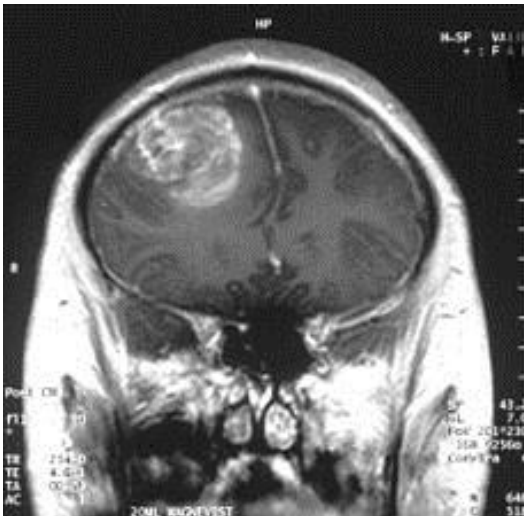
Magnetic Resonance Imaging (MRI) of Glioblastoma Multiforme (image taken directly from Wikipedia.org)⁴
